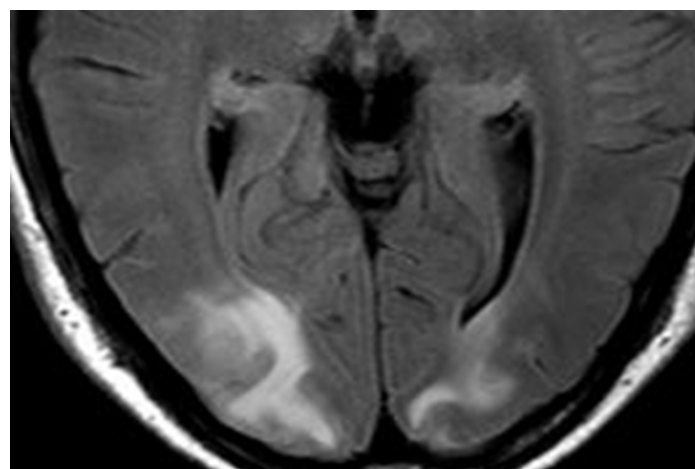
MRI image of a patient with PSGN presenting as PRES
